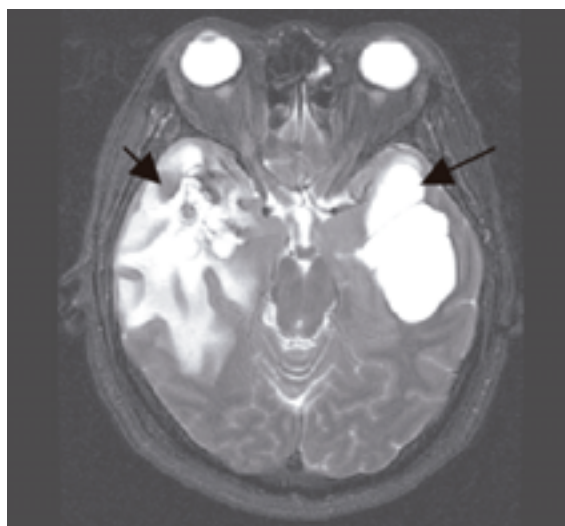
Axial T2-w MR image shows bilateral temporal lobe hyperintensity due to vasogenic oedema (arrows).
